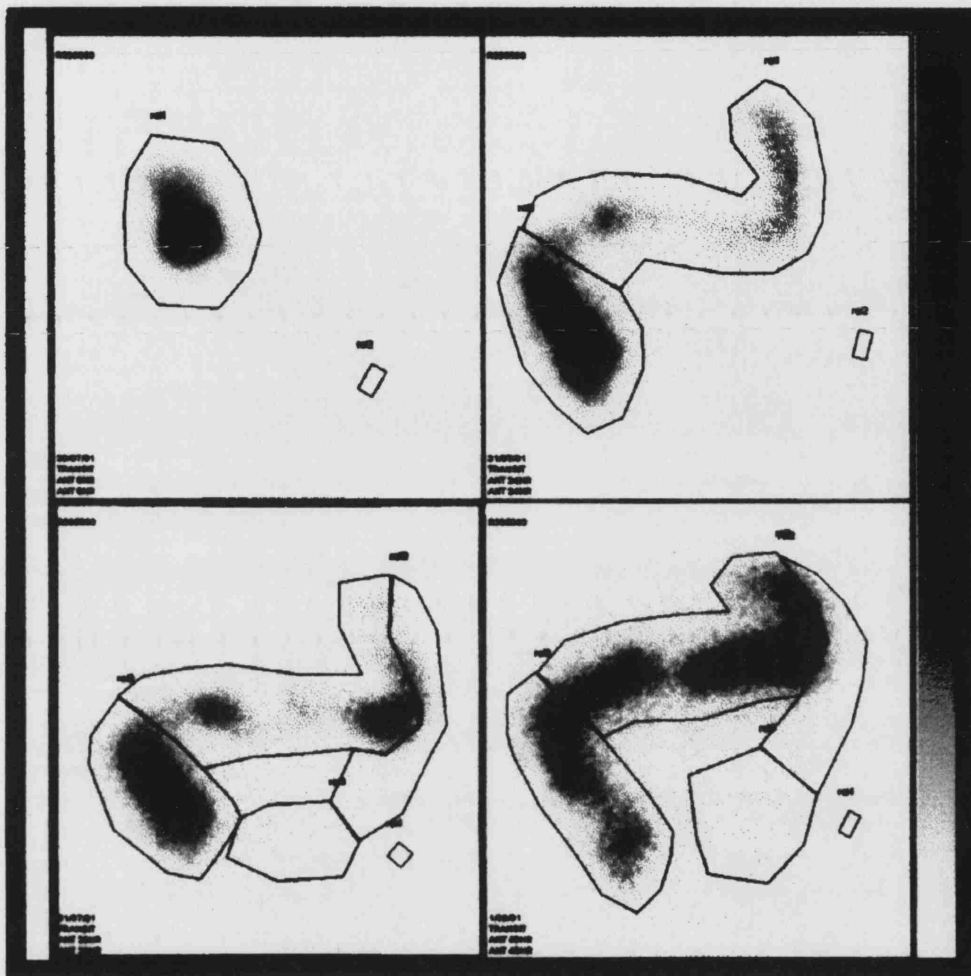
Example of a scintigraphic study showing slow colonic transit. Radioisotope transit is normal through the stomach and small bowel to the caecum. There is retention of the tracer in the right side of the colon at 24, 30 and 48 hours. The tracer has not reached the left side of the colon at 48 hours.
